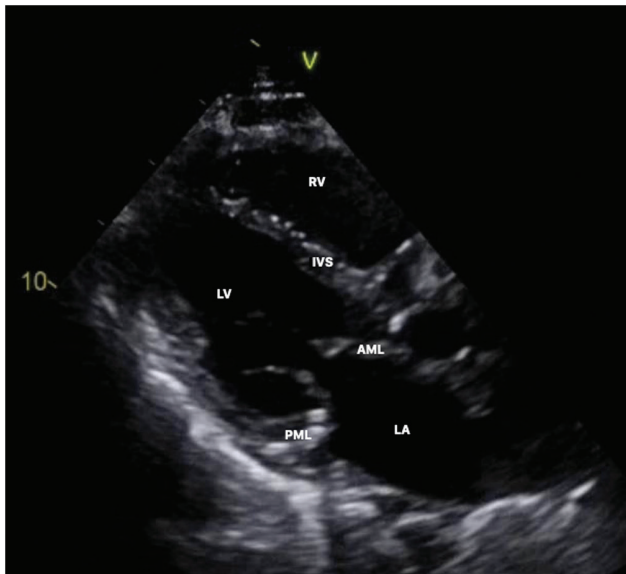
Transthoracic echocardiogram, parasternal long access view obtained couple months before current presentation. AML = anterior mitral leaflet, IVS = interventricular septum, LA = left atrium, LV = left ventricle, PML = posterior mitral leaflet, RV = right ventricle, V = vegetation
